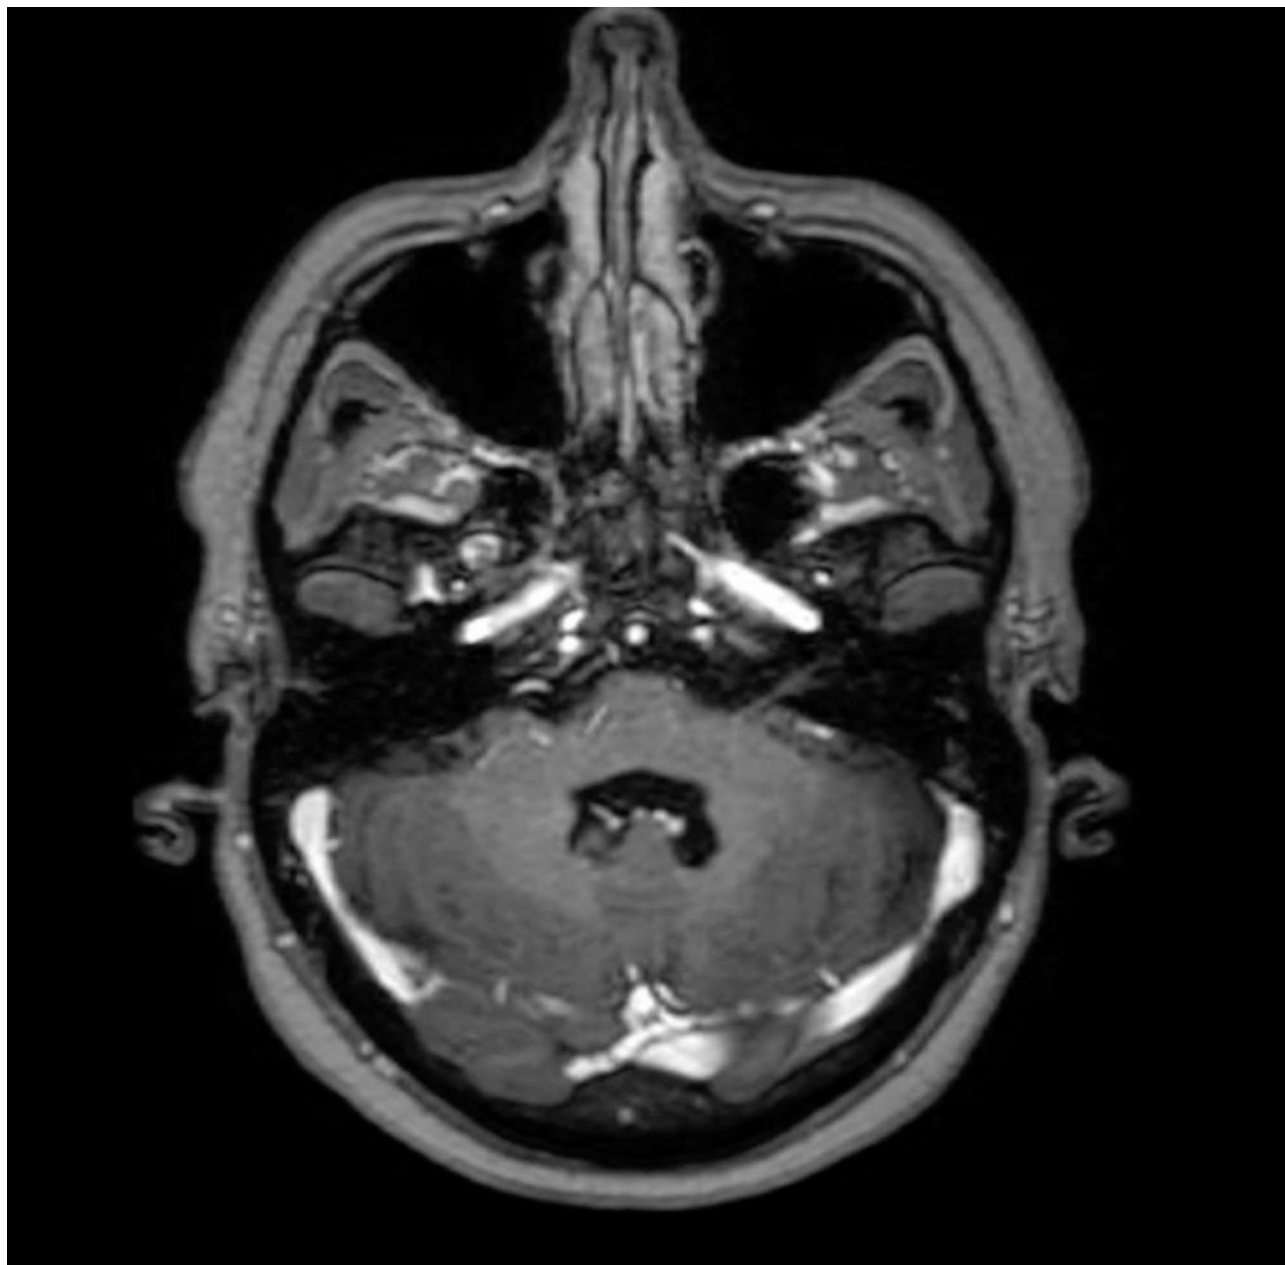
MRI T1 + contrast axial image 3 month after Radiotherapy showing Radiological response compare to Fig. 1.
